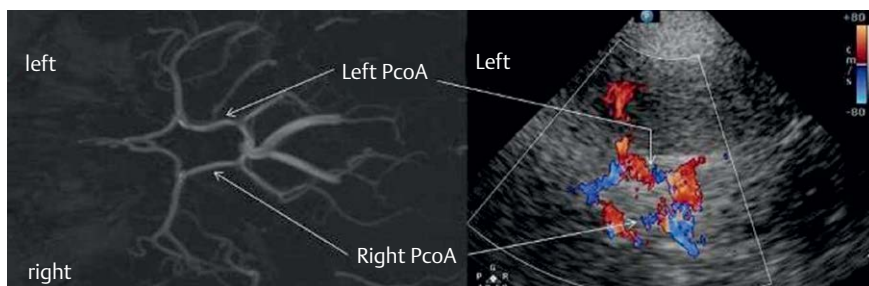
Willis circle visualized on axial time-of-flight magnetic resonance angiography a and transcranial color-coded sonography through the left temporal bone window b.
